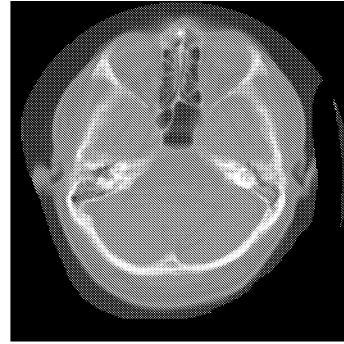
“Bone oriented” CT slice.
